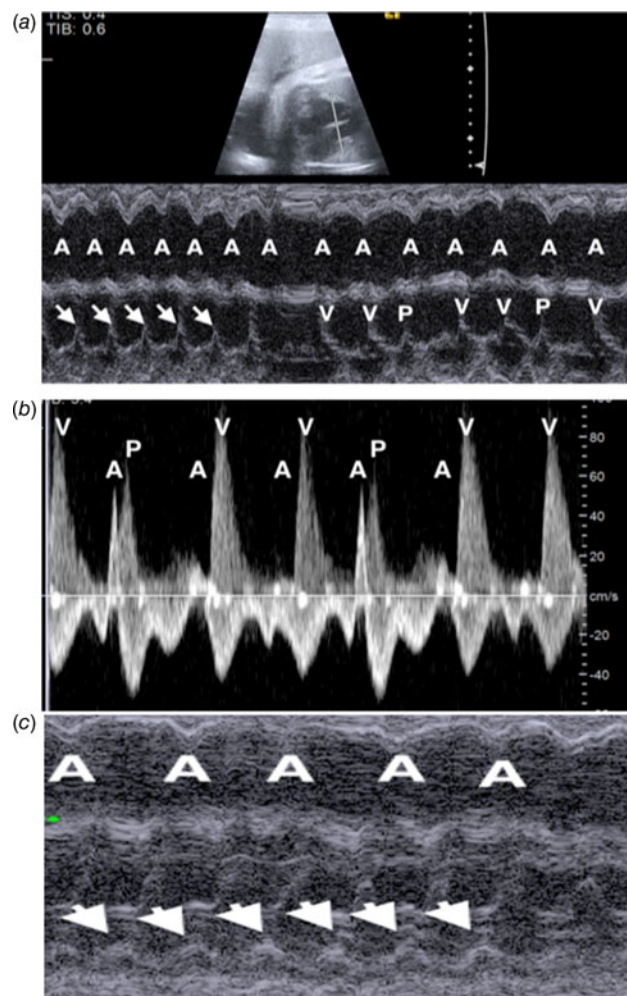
Differentiating VT from JET A: This 34-week fetus presented in tachycardia initially with 1:1 ventricular (arrow) to atrial (A) relationship at 180–190 bpm. When not in tachycardia, the baby was having ventricular trigeminy (P) and otherwise normal A-ventricular (V) synchrony. B: The ventricular ectopy was confirmed by the simultaneous superior vena cava (SVC)-ascending aortic Doppler interrogation with SVC a wave reversal and forward flow through the aorta are shown above the baseline and forward flow through SVC below the baseline. Normal atrial (A) and ventricular (V) contractions are shown, but with a premature ventricular contraction (P) occurring during an atrial contraction, the AV has a very high velocity in keeping with a cannon A wave (atrial contraction against a closed tricuspid valve). C: In addition to the presence of premature ventricular contractions out of tachycardia, the fetus also demonstrated ventricular (arrow)-atrial (A) dissociation at one point in tachycardia with a clearly faster ventricular rate.
